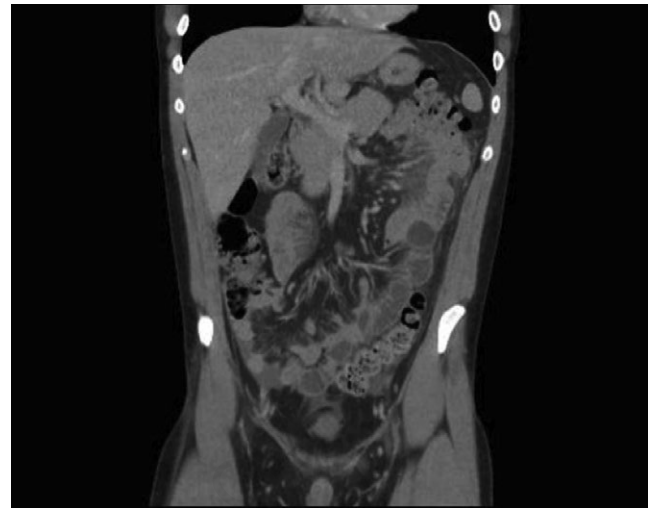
Abdomen computed tomography scan with contrast. A contrast computed tomography scan with evidence of distended small bowel loops, mesenteric thickness, reactive lymph nodes and free intra-abdominal fluid in a patient affected by TRAPS (TNF-receptor associated periodic syndrome).
